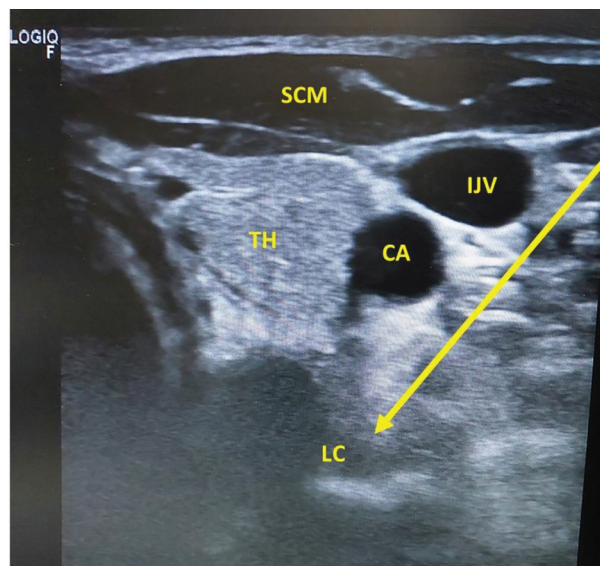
Ultrasonographic guided right stellate ganglion block. Caption: SCM: sternocleidomastoid muscle; TH: thyroid; CA: carotid artery; IJV: internal jugular vein; LC: longus colli; The yellow arrow represents the direction and depth of the needle.
